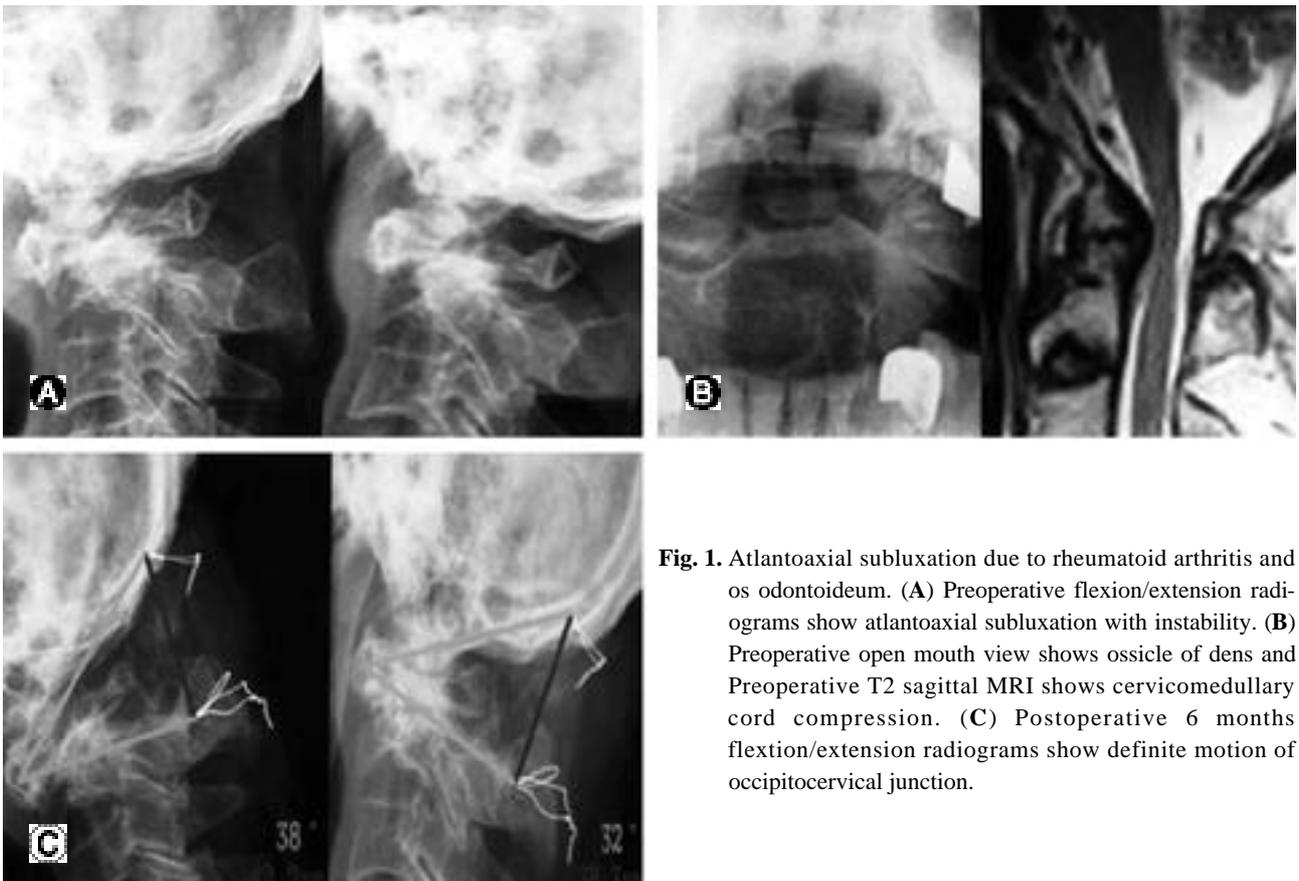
Atlantoaxial subluxation due to rheumatoid arthritis and os odontoideum. (A) Preoperative flexion/extension radiograms show atlantoaxial subluxation with instability. (B) Preoperative open mouth view shows ossicle of dens and Preoperative T2 sagittal MRI shows cervicomedullary cord compression. (C) Postoperative 6 months flexion/extension radiograms show definite motion of occipitocervical junction.
